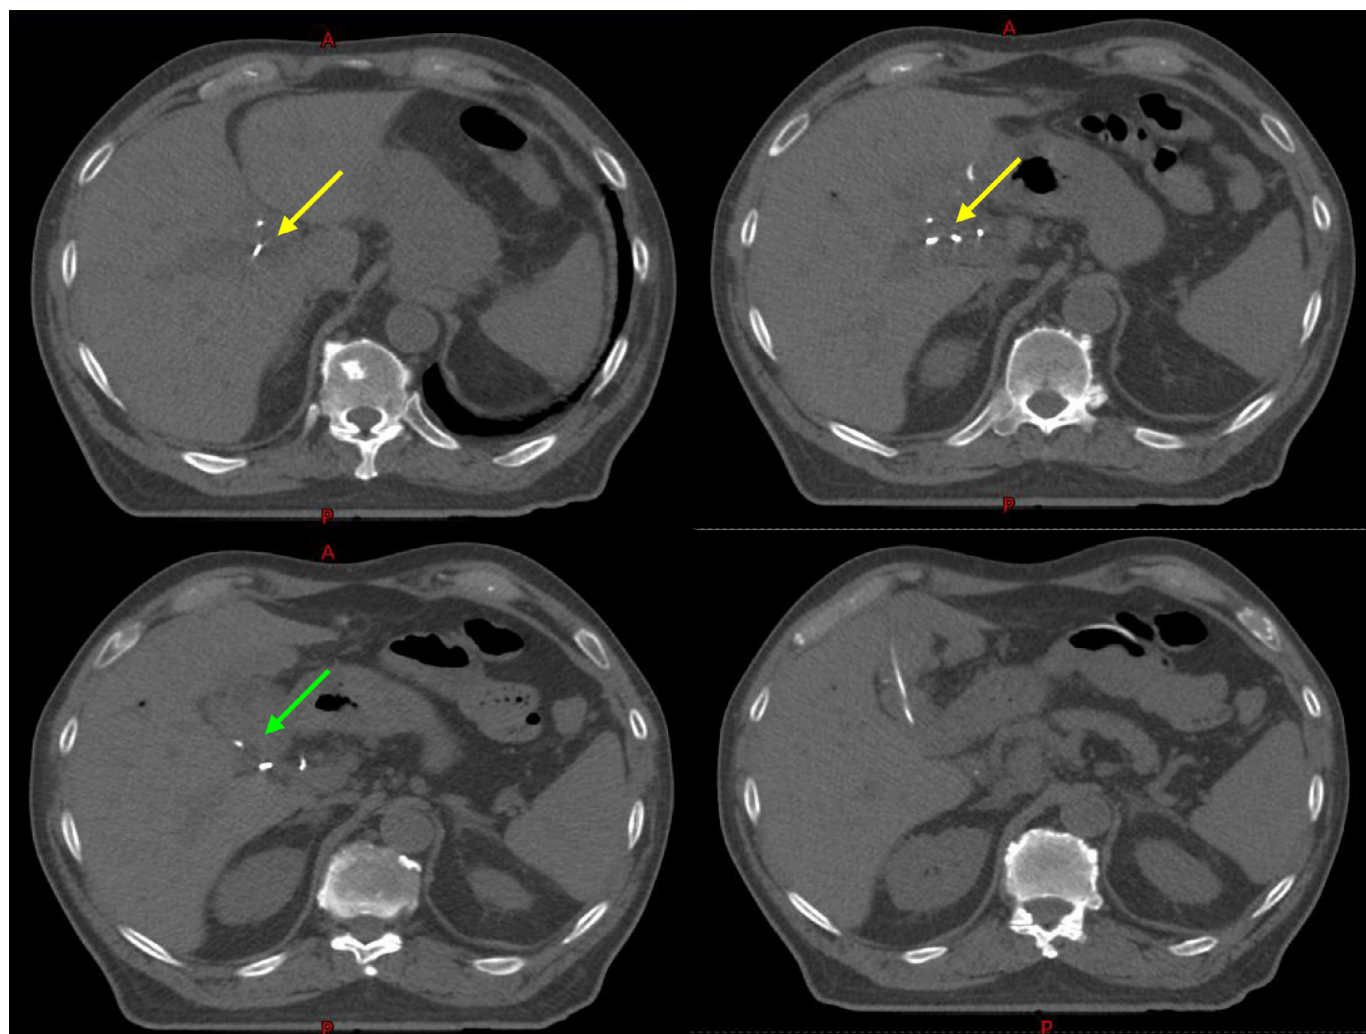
(A) Preoperative computed tomography (CT) axial images of the abdomen (upper panel) with contrast from a patient diagnosed with extrahepatic cholangiocarcinoma showing dilated intrahepatic biliary ducts (blue arrows) and a hilar cholangiocarcinoma (yellow arrows). (B) Postoperative CT axial slices without contrast through the abdomen (lower panel) s/p tumor and extrahepatic bile duct resection, cholecystectomy (green arrows pointed at operative bed) and a Roux-en-Y hepaticojejunostomy (white arrow). (Color version of figure is available online.)
